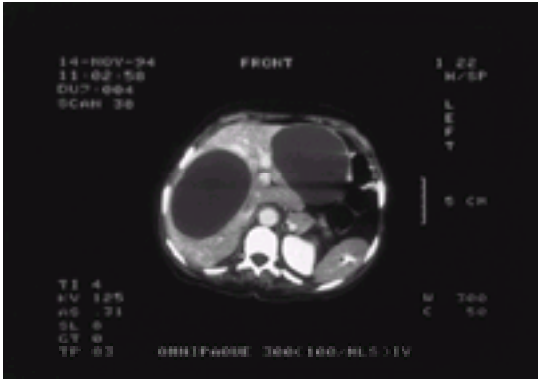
CT scan showing two hydatid cysts in the liver.
